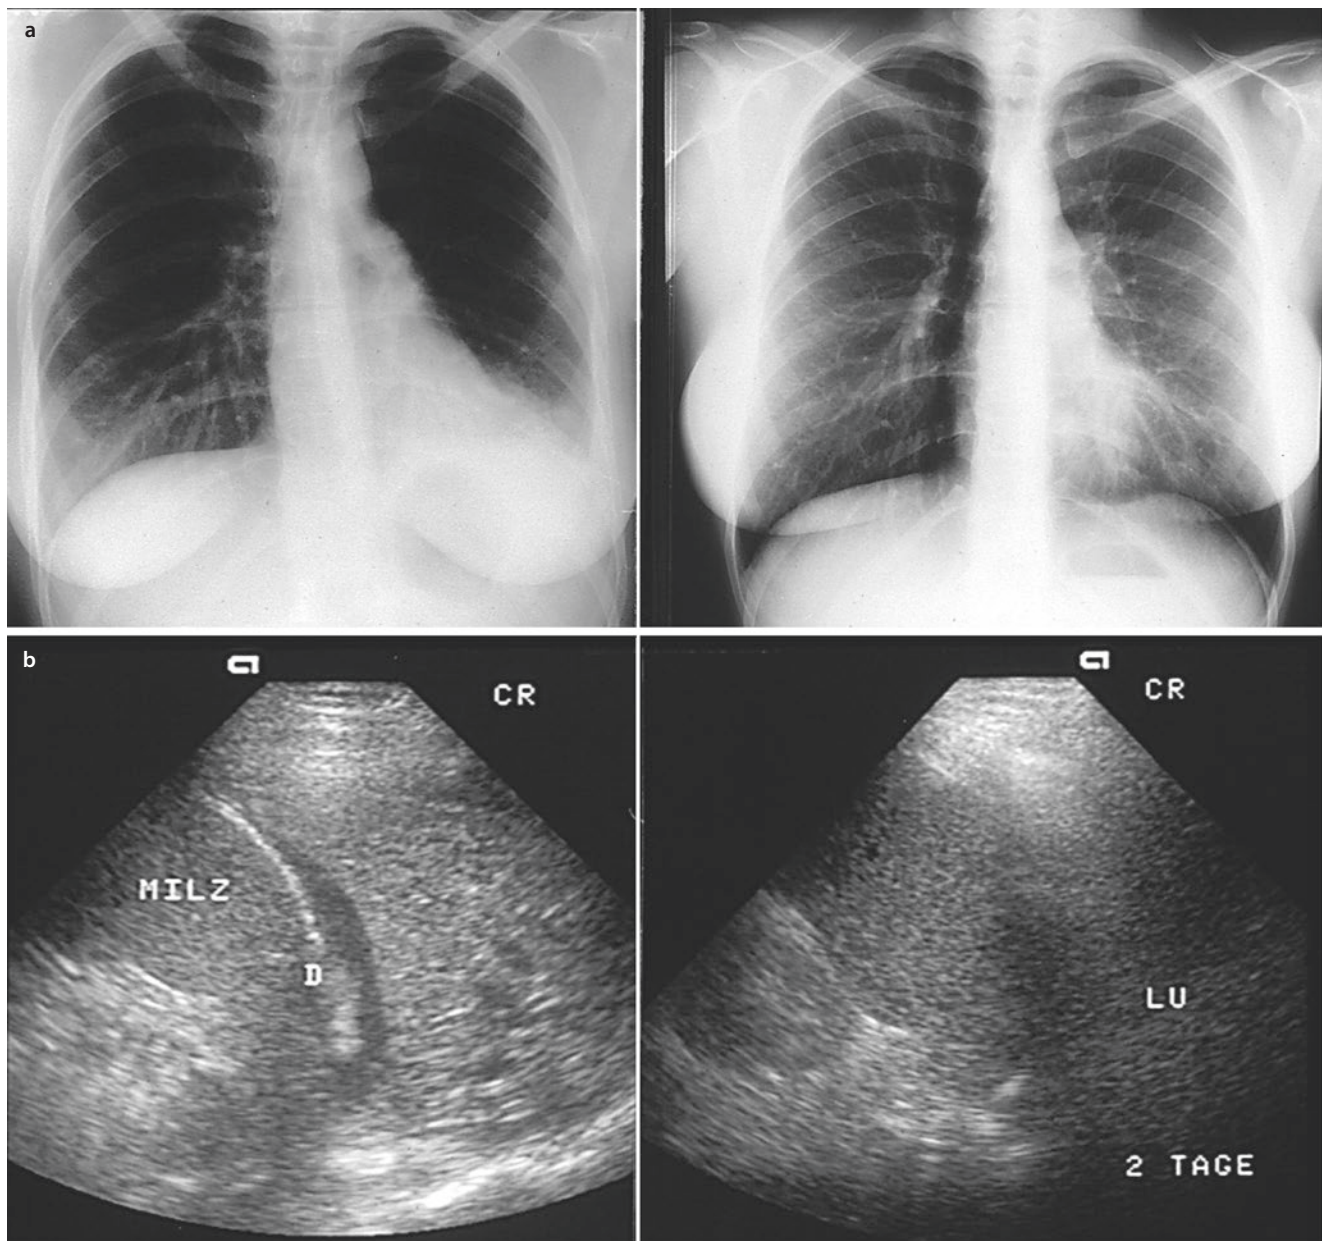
A 20-year-old woman with fever and dyspnea. a Chest X-ray: signs of atelectasis in the lower lobe on the left side (*left*), which resolved spontaneously after 2 days (*right*). b Sonography: left-lateral intercostal echo transmission shows a homogenous lung consolidation
